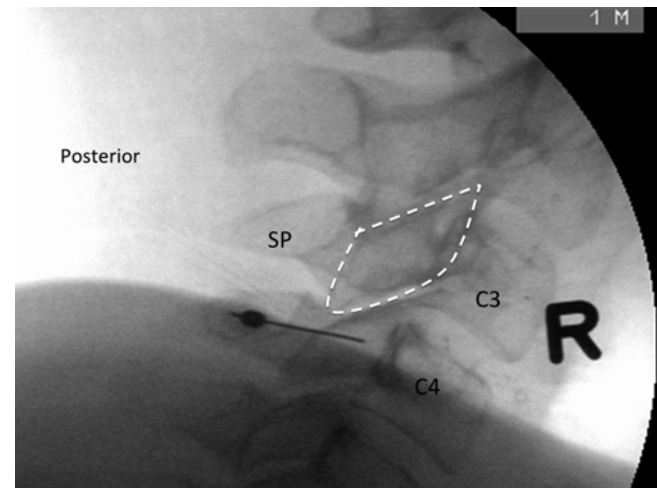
X-ray picture showing the target of the facet medial branch block. The target is the intersection of the diagonal lines of the trapezoid (articular pillar). *SP* spinous process. (With permission of Dr. Andreas Siegenthaler)
